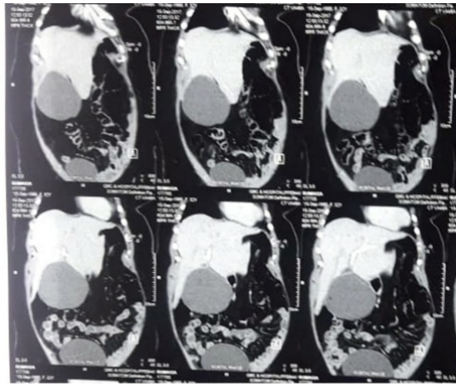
MRI image revealing a cystic image in the liver
